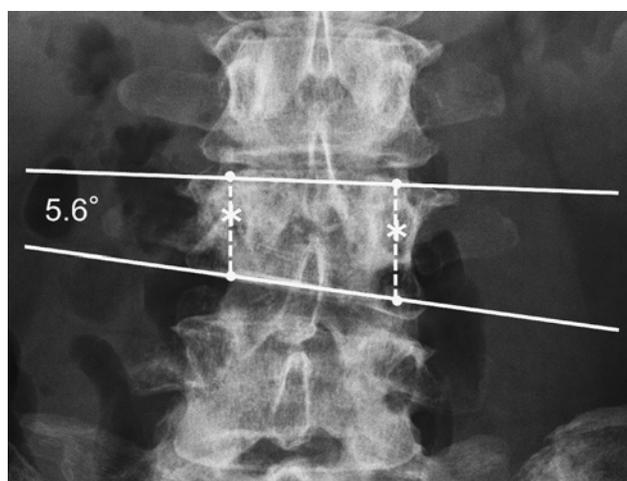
Radiographic imaging of a 55-year-old woman with 4th lumbar vertebra metastasis of breast cancer. Radiographs show asymmetrical vertebral collapse over 5 degrees.
